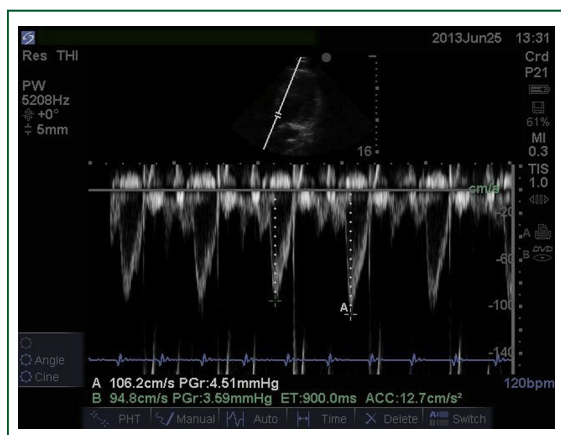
The respiratory variation of blood flow at the level of the left ventricular outflow tract using pulsed wave Doppler. Maximal velocities at different phases of the respiratory cycle are compared.
